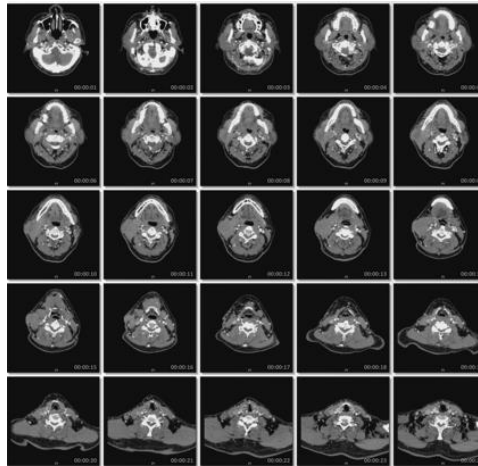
CT-Scan cervical showed a mass in the right parotid gland
